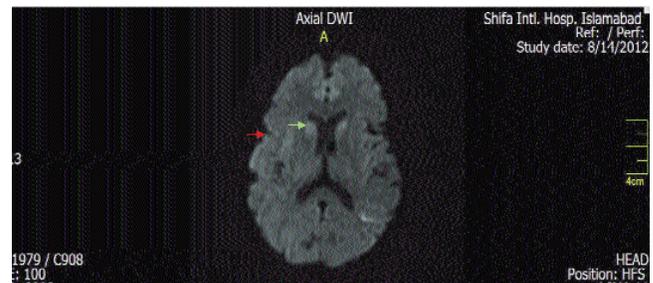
Subtle increased signal in bilateral caudate nucleus (green arrow) and subcortical ribboning (red arrow) on DWI.
